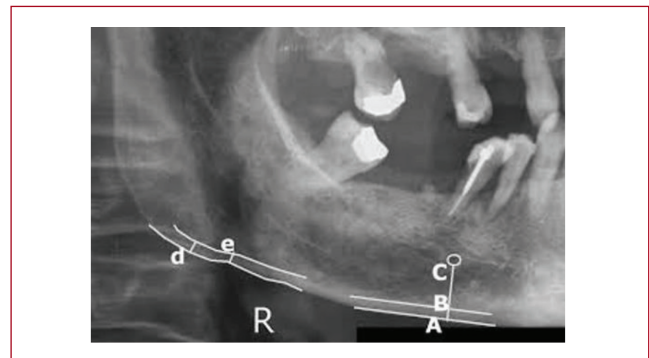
Measurements estimated in panoramic X-rays: Mandibular Cortical Width (MCW) or Mental Index or Cortical Width Index: line AB; Panoramic Mandibular Index (PMI): ratio AB/AC; Gonial Index (GI): line d; Antigonial Index (AI): line e; white circle: mental foramen.
